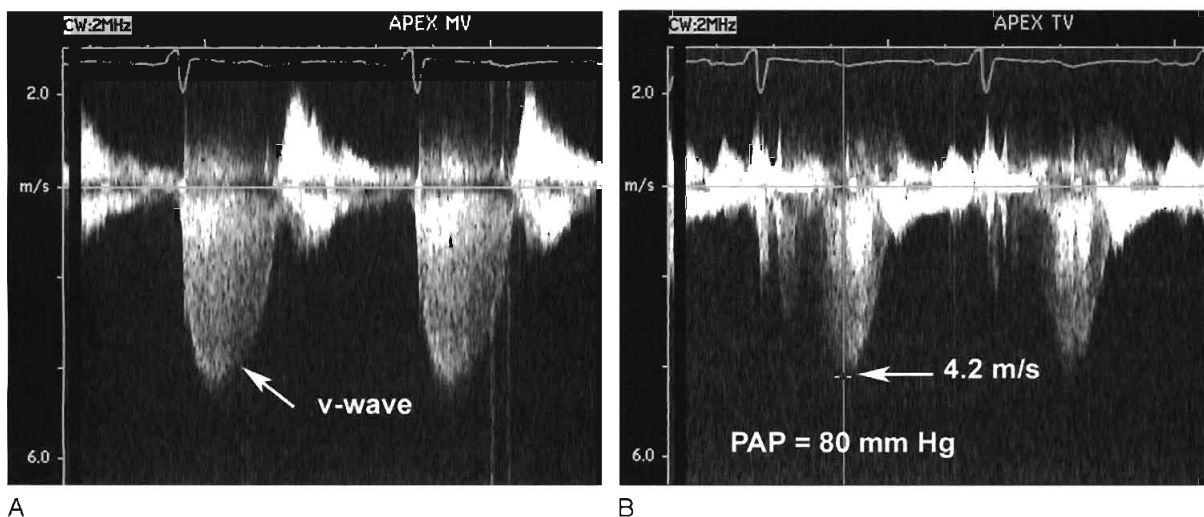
In the same patient as Figure 103-2 severe mitral regurgitation was recorded with continuous wave Doppler ultrasound (A). The rapid rise in left atrial pressure due to the regurgitant jet entering the left atrium results in a rapid decline in the Doppler velocity in late systole—the Doppler equivalent of the v wave seen on a pulmonary wedge pressure tracing. The continuous wave Doppler recording of the maximum tricuspid regurgitant jet velocity (B) of 4.2 m/s indicates a right ventricular to right atrial pressure difference of 70 mm Hg. The patient's right atrial pressure was estimated to be 10 mm Hg, based on the size and respiratory variation in the inferior vena cava, so that the estimated pulmonary systolic pressure is 80 mm Hg.
